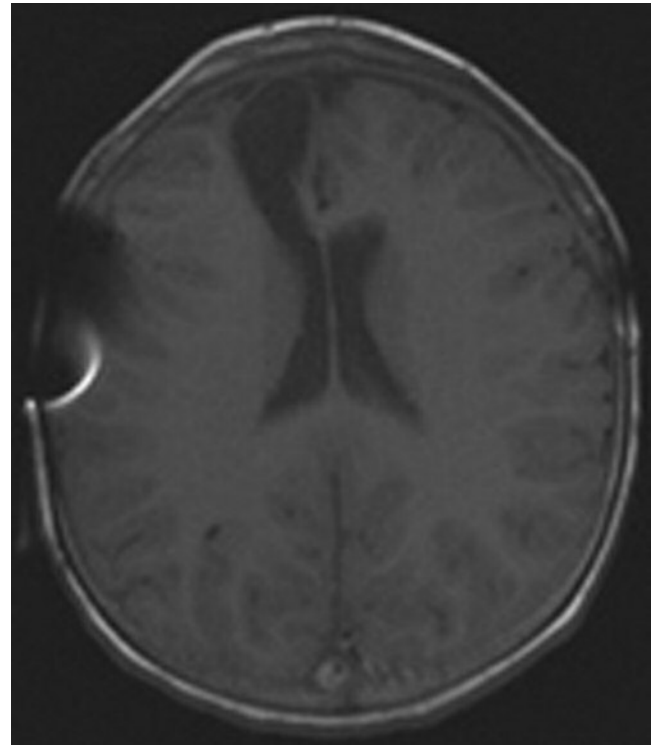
An MR image obtained 2 years after surgery, demonstrating the residual tissue loss where cortex herniated through the inner membrane and pial defect. The artifact from the subdural shunt is visible, but the extracerebral fluid collections have resolved.
